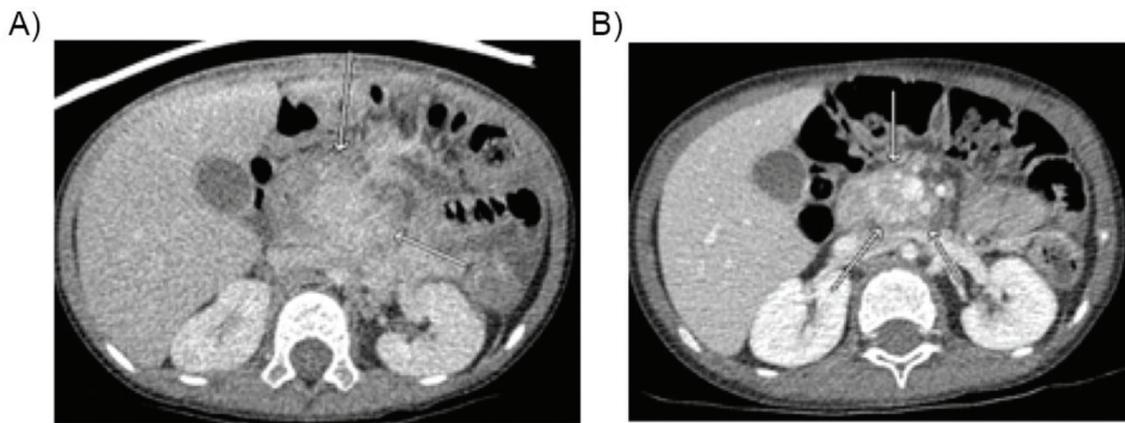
Radiographical change of kaposiform hemangioendothelioma after being treated with sirolimus (arrows indicate boundary of tumor). A) before treatment with sirolimus B) 180 days after treatment with sirolimus.
